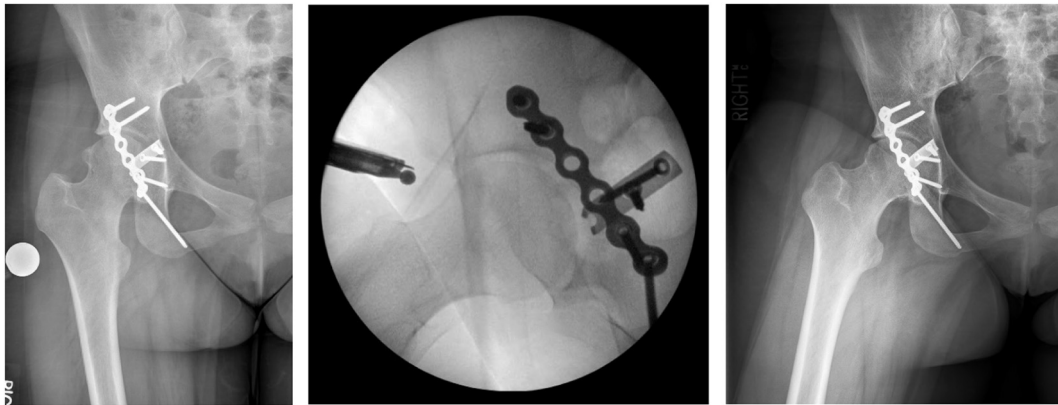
A–C. A). Preoperative radiograph taken before hip arthroscopy and femoral osteochondroplasty. B). Dunn view taken with fluoroscopy intraoperatively and C). Follow-up radiographs taken 1 year after hip arthroscopy and femoral osteochondroplasty. Note that there is no evidence of recurrence at 1 year following osteochondroplasty.
